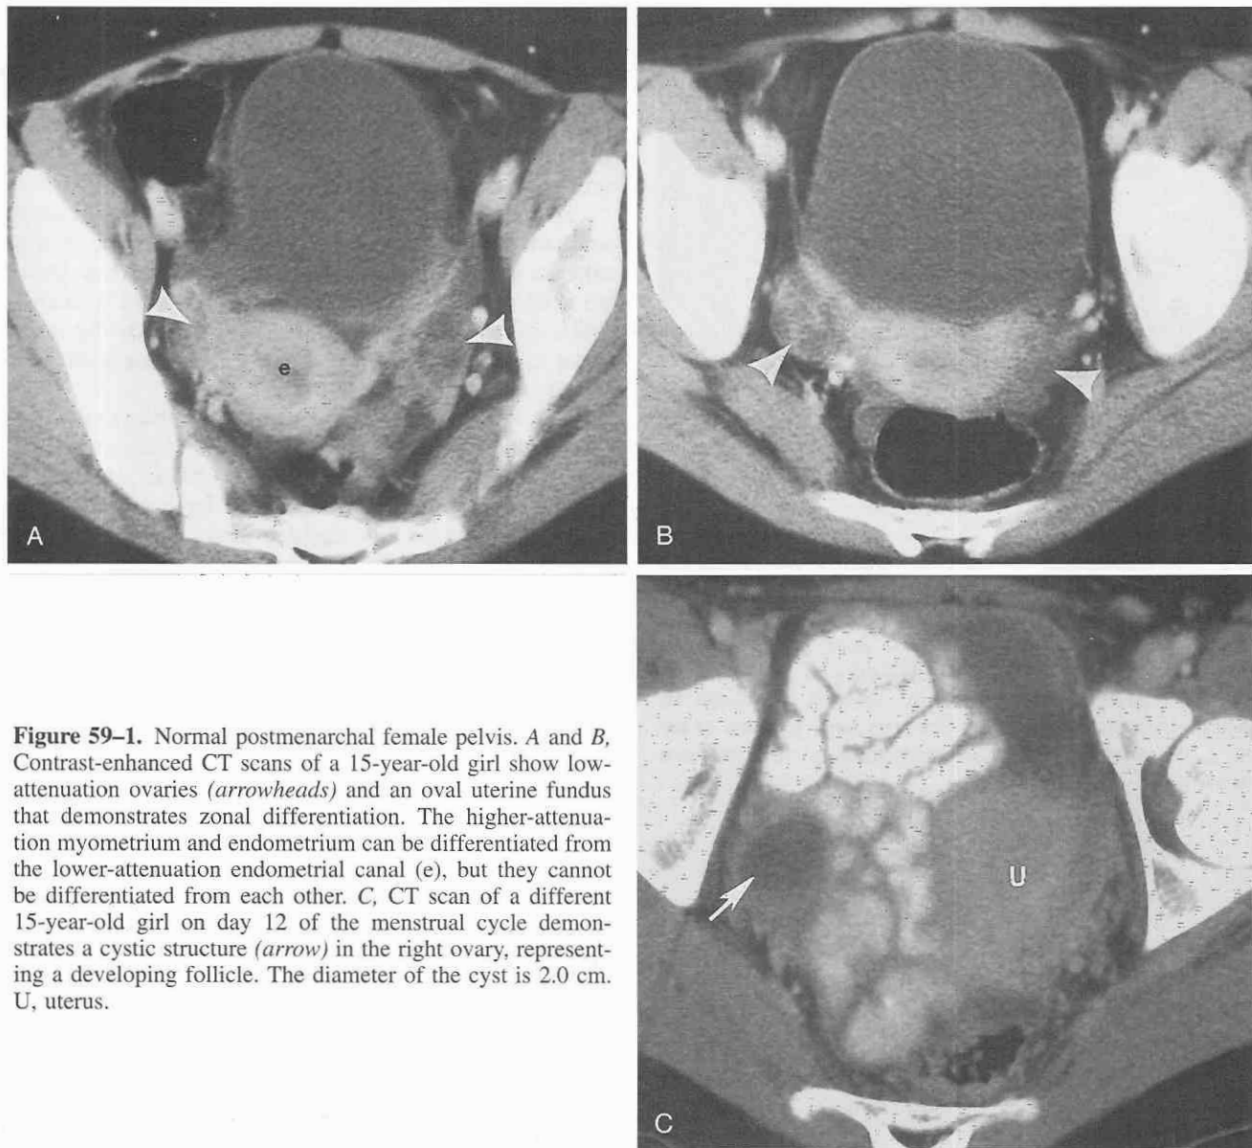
Normal postmenarchal female pelvis. A and B, Contrast-enhanced CT scans of a 15-year-old girl show low-attenuation ovaries (arrowheads) and an oval uterine fundus that demonstrates zonal differentiation. The higher-attenuation myometrium and endometrium can be differentiated from the lower-attenuation endometrial canal (e), but they cannot be differentiated from each other. C, CT scan of a different 15-year-old girl on day 12 of the menstrual cycle demonstrates a cystic structure (arrow) in the right ovary, representing a developing follicle. The diameter of the cyst is 2.0 cm. U, uterus.
